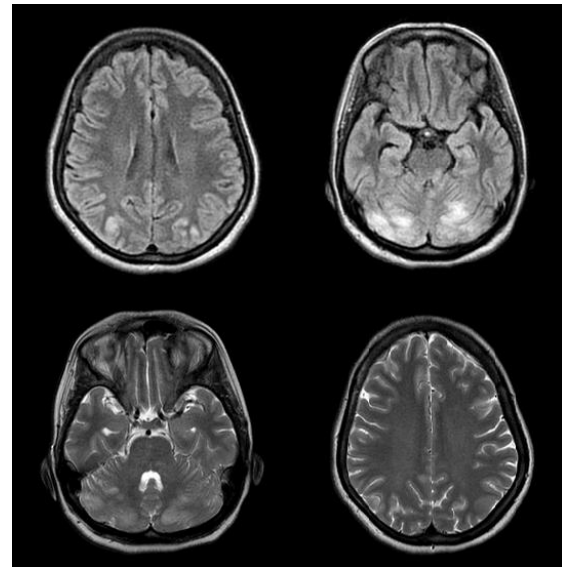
A 32-year-old female presented with post-partum headache and diminution of vision. MRI scan was performed and T2 and FLAIR hyperintense signal intensity was noted in bilateral parietal and occipital lobes.
